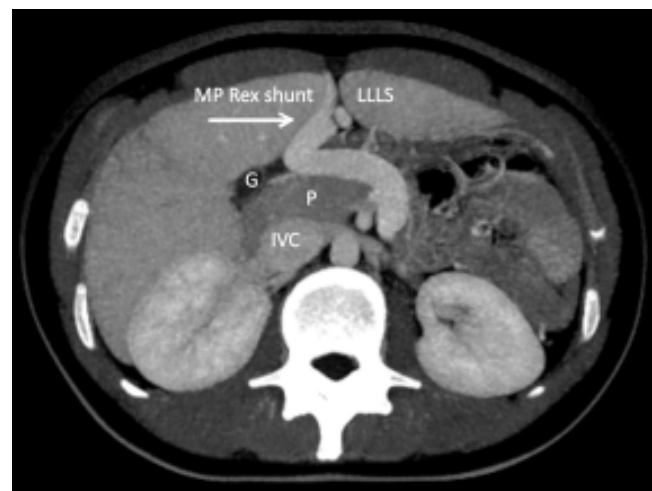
CT angiography of case 1 shows a congenital mesenterico-portal (MP) Rex shunt (arrow). LLLS: Liver's left lateral segment. G: Gallbladder. P: Pancreas. IVC: Inferior vena cava.
